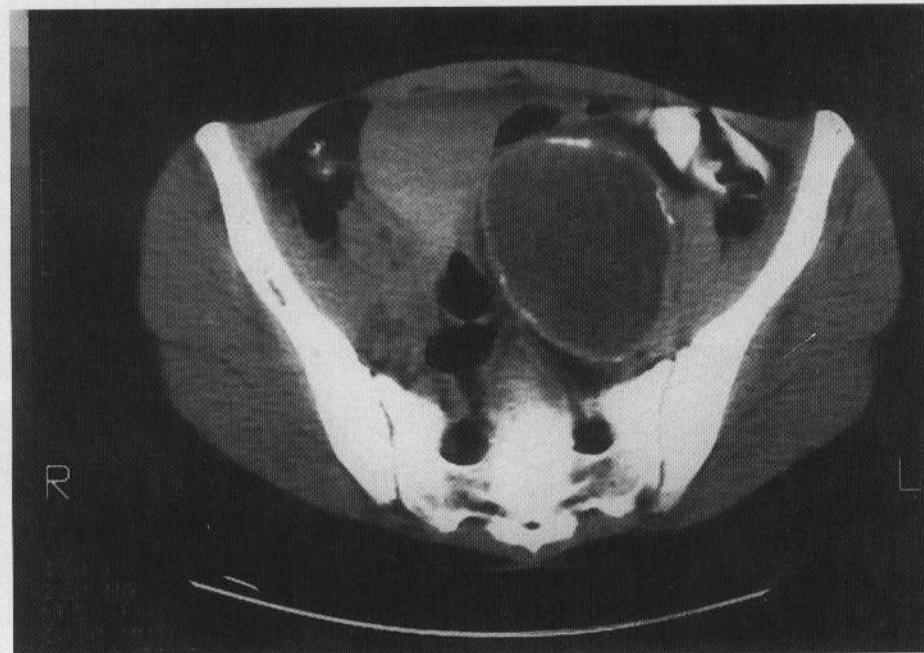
CT scan showing a hydatid cyst in the left iliac fossa.
